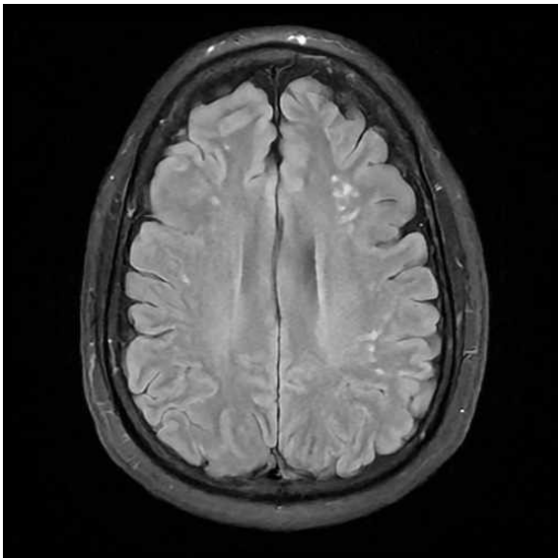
Axial plane FLAIR MRI of white matter hyperintensities.
